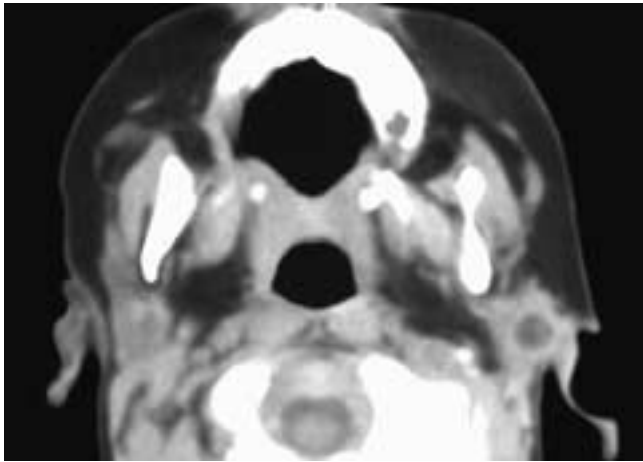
Axial CT scan shows a small cyst in the uppermost left parotid gland just caudal to the external auditory canal. This child had a type 1 first branchial cyst.
